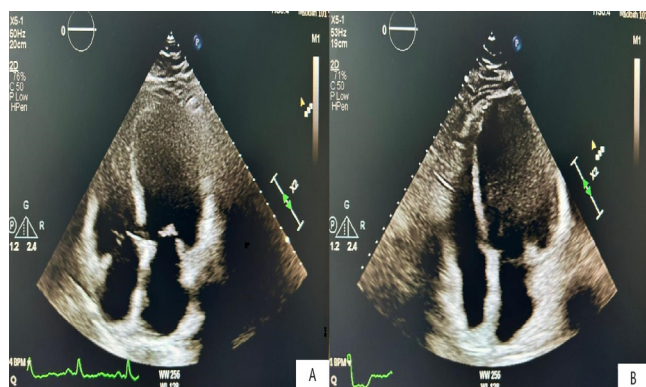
Comparison of patient's echocardiogram between December 2022 (A) and March 2023 (B).
